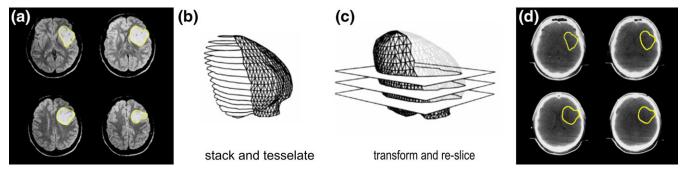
Structure Mapping. (a) Tumor volume outlined on a secondary image (e.g., MR in this case). (b) Outlines stacked and tessellated to create a surface representation. (b) The MR-based surface is mapped to the CT coordinate system and resliced along the image planes of the CT study. (d) The derived contours are displayed over the CT images. [Color figure can be viewed at wileyonlinelibrary.com]
